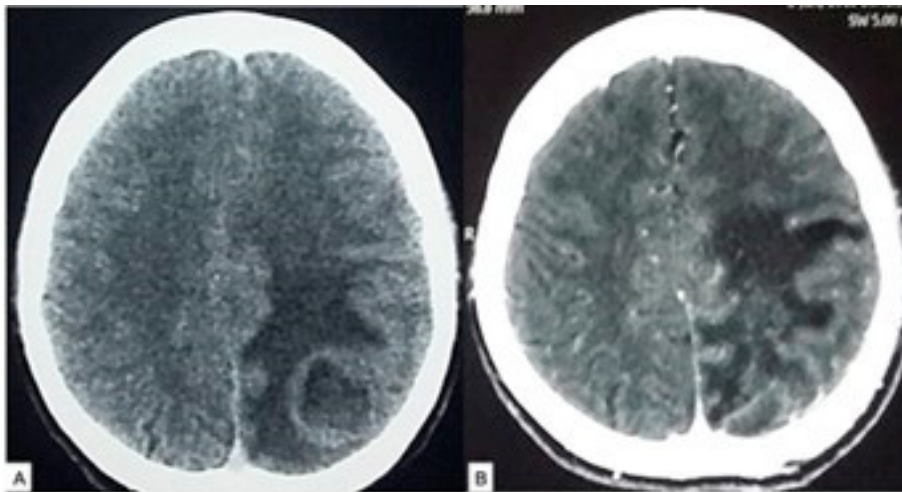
Pre- (A) and (B) postoperative (craniotomy) CT of a brain abscess. Source: Figure by authors.
